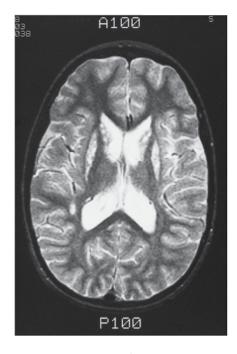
MH: Neuroimaging (magnetic resonance imaging) of the brain reveals hyperlucency of the striatum as well as an extraordinary pattern of increased T_2 signal in the white matter.
